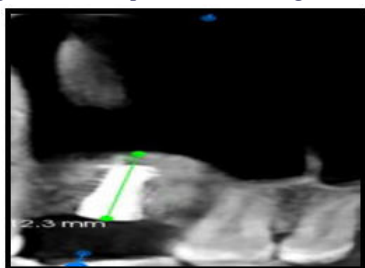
Post-Operative Bone Height CBCT
